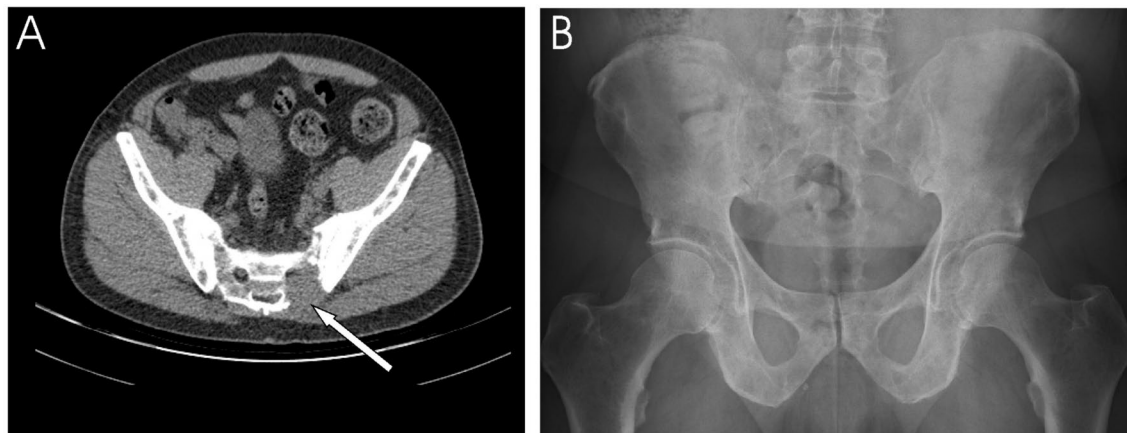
Low-dose CT versus conventional X-ray. Low-dose CT (A) and conventional X-ray (B) of a 67-year-old man with newly diagnosed multiple myeloma. X-ray performed 7 days after low-dose CT-scanning. The CT-scan shows a significant osteolytic lesion, not visualised at X-ray, of the pelvic area.
